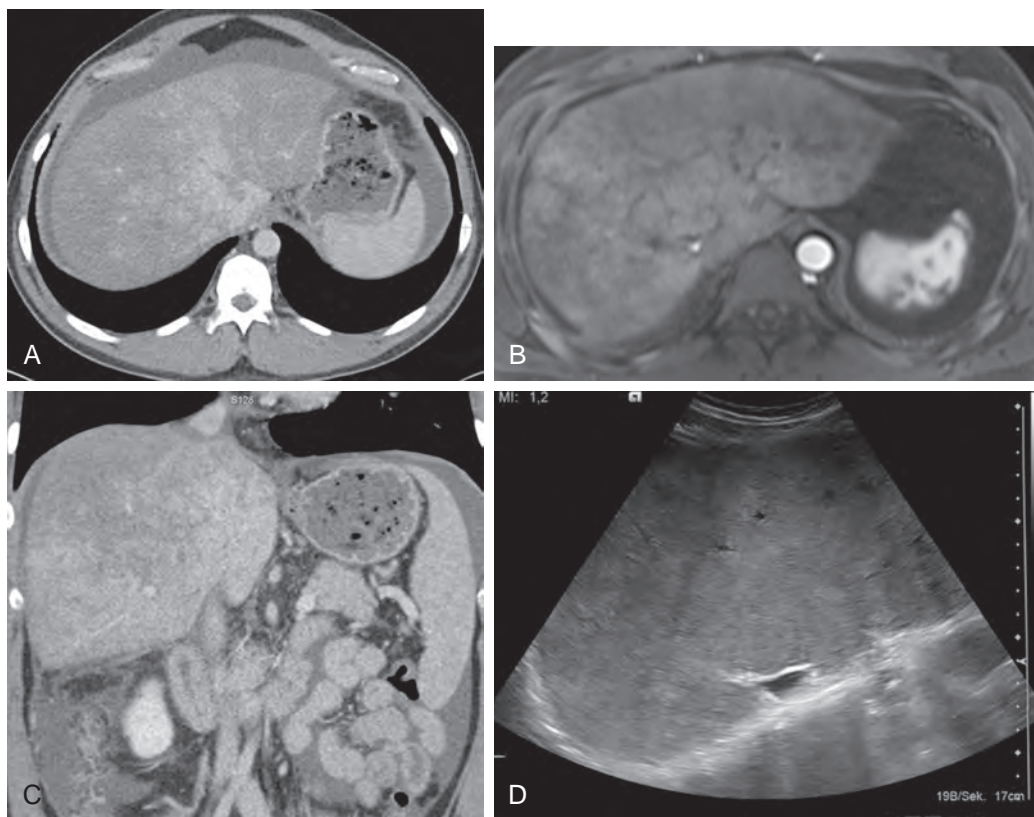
Budd-Chiari syndrome: CT features with MR and ultrasound correlation. CT (A), MR (B and C), and sonographic (D) images of the liver show a mottled contrast enhancement pattern and narrowing of the inferior vena cava and no discernible hepatic veins.
